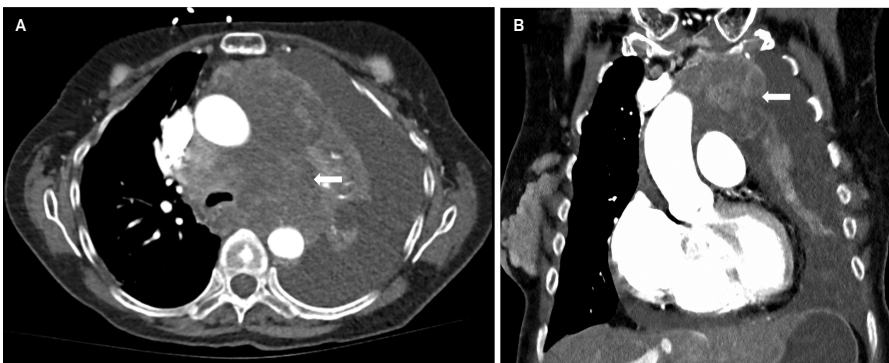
Necrotic mediastinal lymph nodes. (A, B) Axial and coronal contrast CT images show conglomerated enlarged mediastinal lymph nodes in the prevascular and visceral mediastinum. Extensive necrosis of lymph nodes is seen, mimicking complex cystic mediastinal lesions.
